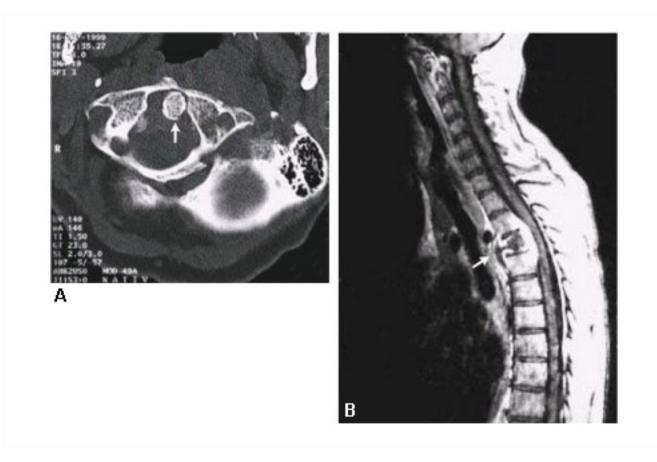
CT showing spinal TB (Pott's disease)
